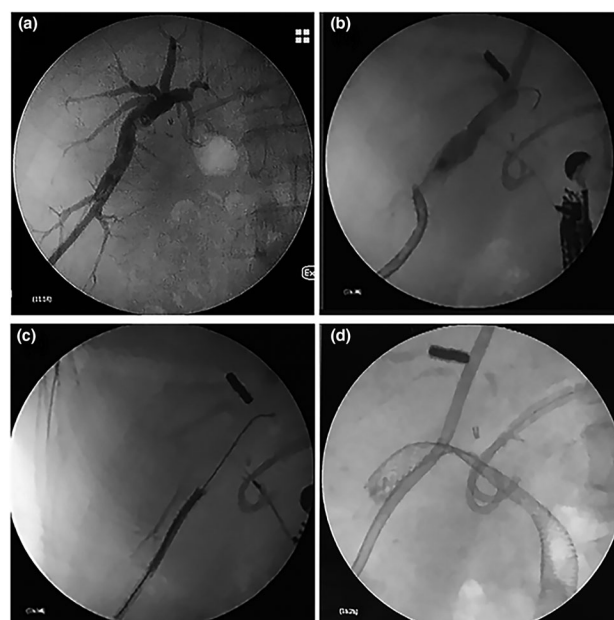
(a) Right intrahepatic bile duct cholangiogram showed right intrahepatic bile duct obstruction. (b) Endoscopic ultrasound (EUS)-guided right intrahepatic bile duct puncture using 22-G needle was performed followed by 0.018-inch guidewire insertion. (c) Percutaneous choledochoscope was inserted and the 0.018-inch guidewire was retracted through the skin. (d) With the aid of percutaneous wire traction, the fully covered metal stent could be placed across the fistula.
